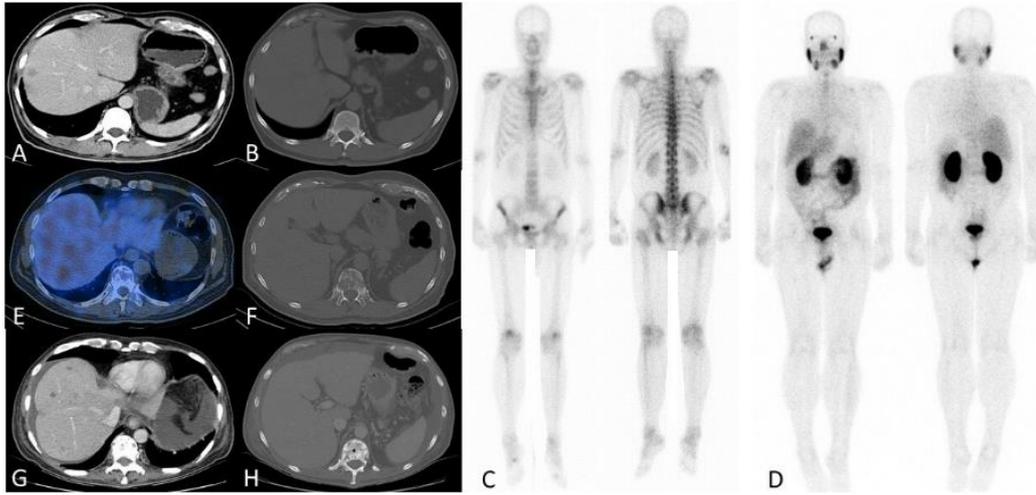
(A) Whole body bone scan; (B) Whole body [^{99m}Tc]Tc-HYNIC-PSMA scan; (C and D) CT scan from the liver and thoracic vertebra for initial staging; (E) SPECT/CT from the liver with no abnormal uptake; (F) CT component of the [^{99m}Tc]Tc-HYNIC-PSMA; (G and H) Post chemotherapy CT scan
